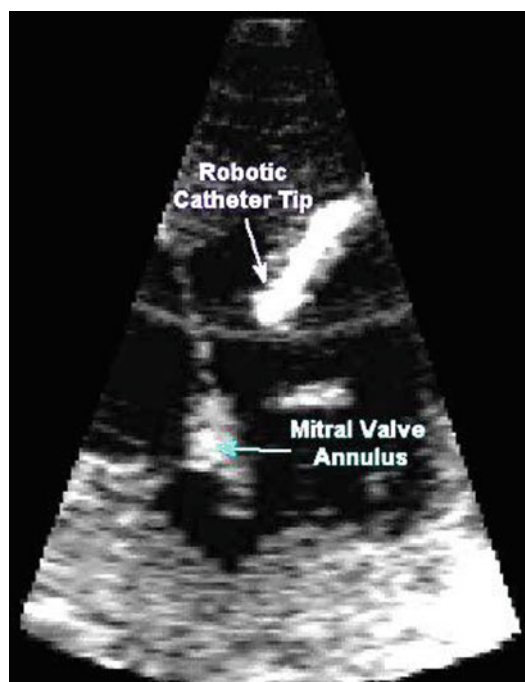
3D-echocardiography image of the catheter-based Motion Compensation Instrument
